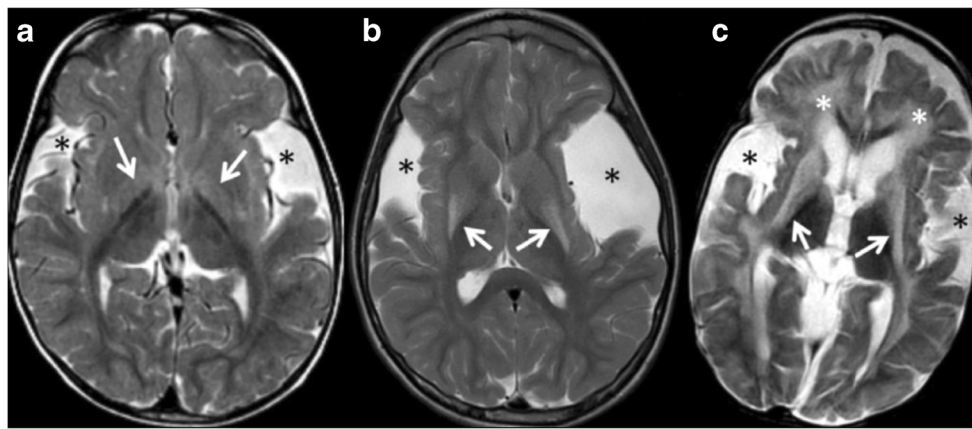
Three different MRI phenotypes of glutaric aciduria type 1 (GA1). A 2-year-old patient (a) showing mild enlargement of the Sylvian fissures (*dark asterisks*) and mild alterations in the globus pallidus (*arrows*). A 14-month-old patient (b) with cystic enlargement of the Sylvian fissures
